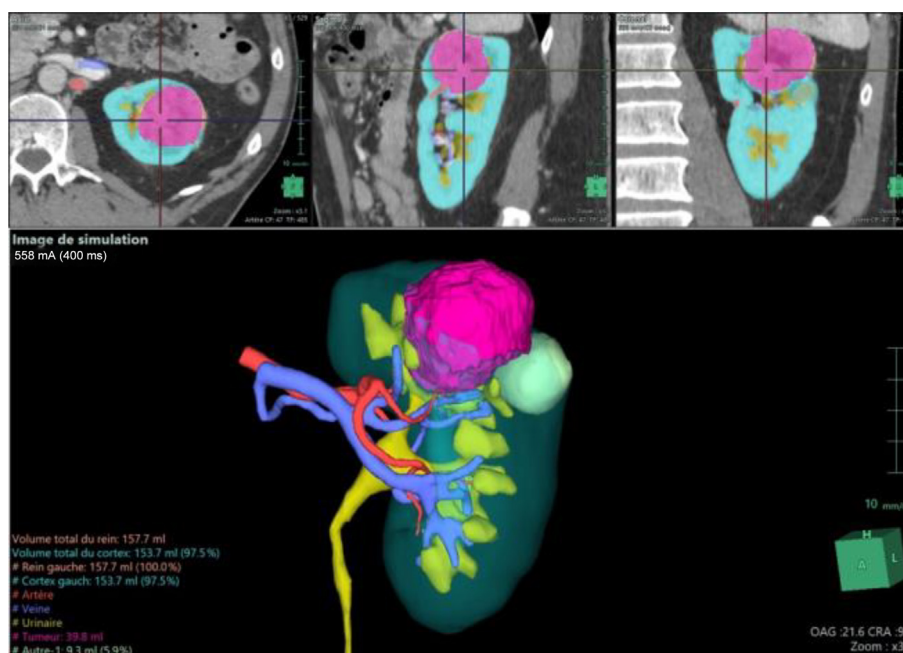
Three-dimensional reconstruction by segmentation of the preoperative CT scan using Synapse 3D software (Fujifilm). CT = computed tomography.
